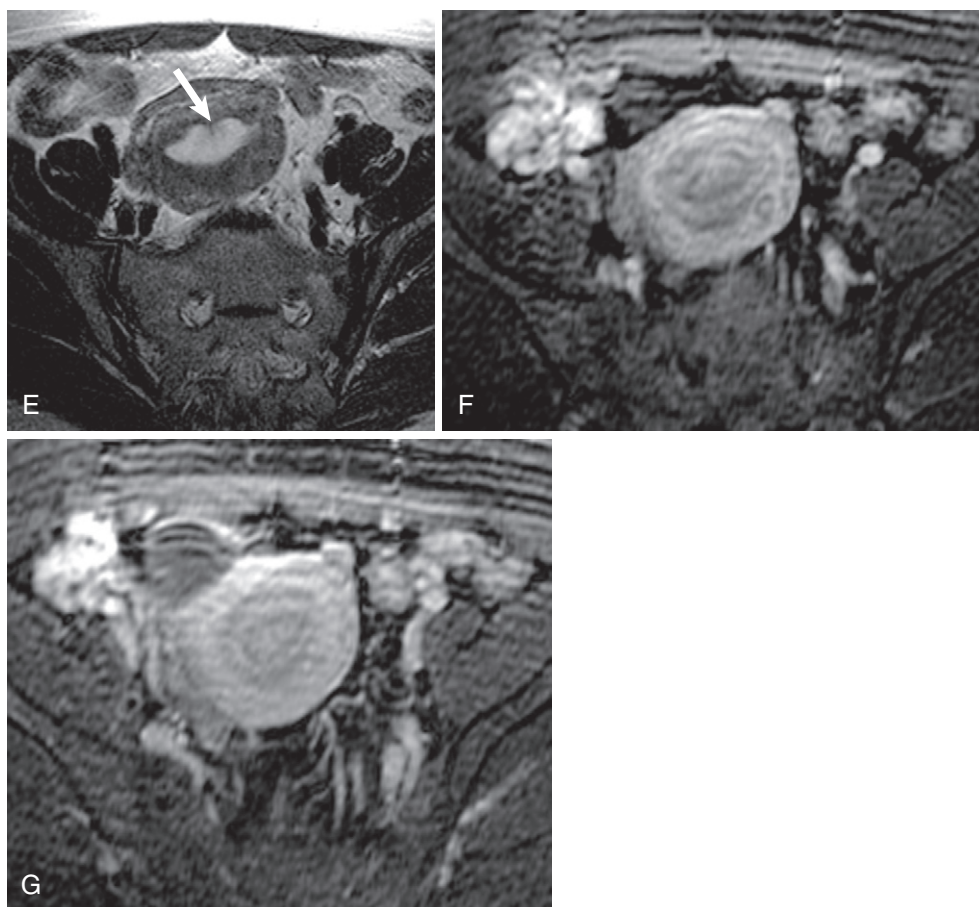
cont'd The sagittal fat-suppressed (C) and axial (D and E) T2-weighted images reveal a more hyperintense tubular lesion (*thin arrow* in C and D) with a well-defined stalk with a hypointense core (*thick arrow* in E). Early (F) and delayed (G) enhanced images show clear delineation of the mass and lacy or textured and more avid enhancement compared with endometrial carcinoma. Note the T2 hypointense (shading) right adnexal lesion—an endometrioma—abutting the anterior uterine fundus (*thick arrow* in D).
